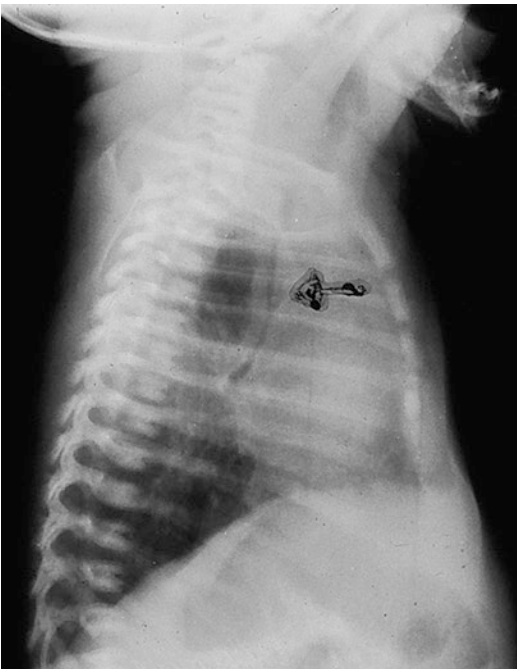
The telltale x-ray sign of TM is a very narrow upper trachea just below the clavicle, seen on a lateral chest x-ray (arrow)
